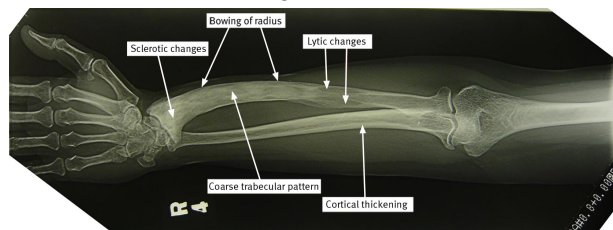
Radiograph of the right forearm showing sclerosis of the distal radius and lytic lesions in the shaft of the radius
